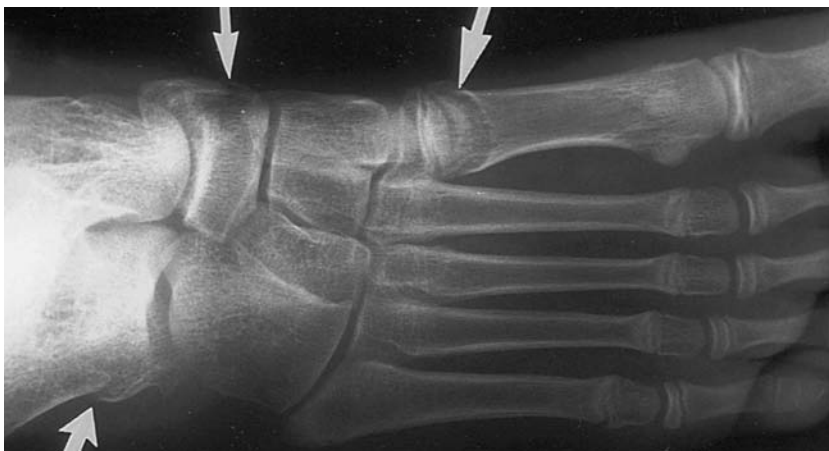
Radiograph of the right foot of a 13-year-old boy demonstrating fractures of the calcaneus (*small arrow*), scaphoid (*medium arrow*), and the first metatarsal (*large arrow*).
